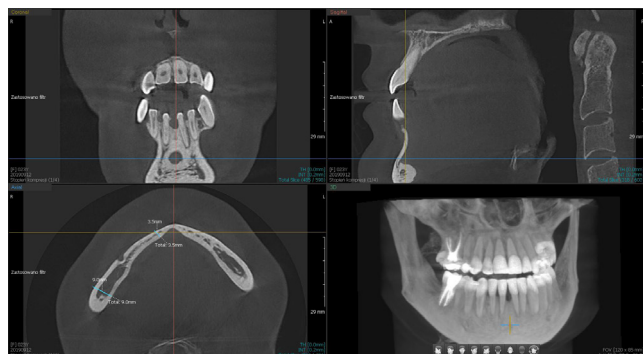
Case 1: Images collected from the cone-beam computed tomography (CBCT) examination
